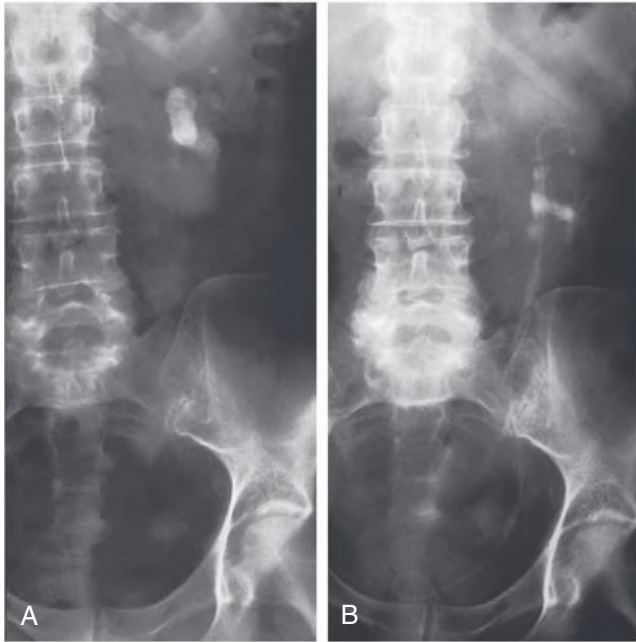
Extracorporeal Shock Wave Lithotripsy (ESWL) Complicated by Stone Fragments Obstructing the Distal Ureter. (A) Preoperative plain radiograph showing stones in the left kidney pelvis. (B) After ESWL, note the disappearance of the pelvic stone, the string of stone fragments throughout the length of the ureter, and the double-J ureteral stent placed to facilitate their passage.
